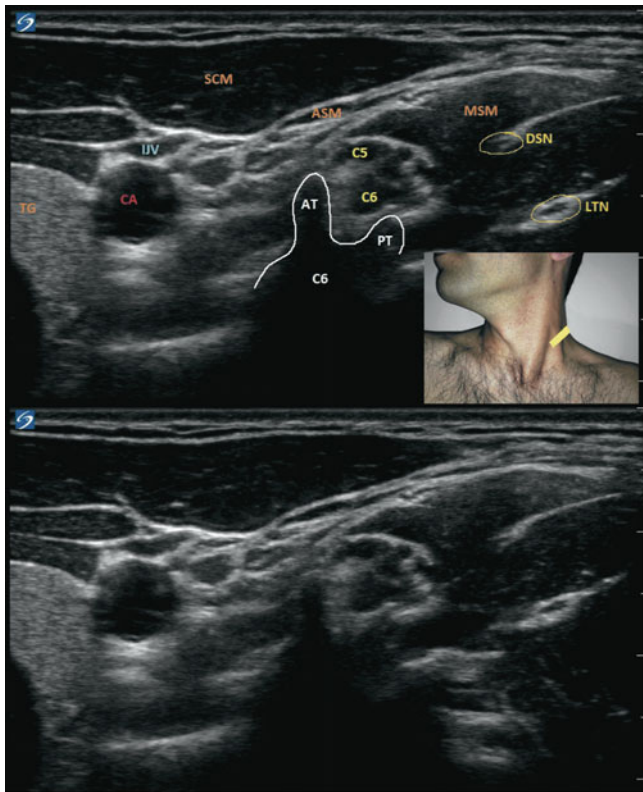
Ultrasound identification of the dorsal scapular nerve at the middle scalene muscle. *SCM* sternocleidomastoid muscle, *MSM* middle scalene muscle, *ASM* anterior scalene muscle, *TG* thyroid gland, *CA* carotid artery, *AT* anterior tubercle of C6 vertebra, *PT* posterior tubercle of C6 vertebra, *DSN* dorsal scapular nerve, *LTN* long thoracic nerve (Image courtesy of Agnes Stogicza, MD)
